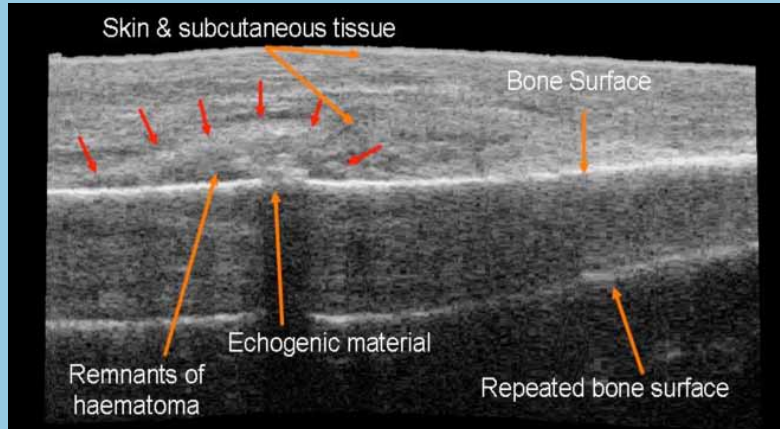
2D Ultrasound of Healing Osteotomy
